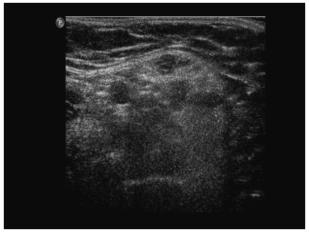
Abnormal transverse quadriceps muscle ultrasound in a child with spinal muscular atrophy. The image shows increased subcutaneous fatty tissue, and a "moth-eaten" appearance representing areas of denervated atrophic fibers versus reinnervated, hypertrophic muscle fibers (the "moth holes").
